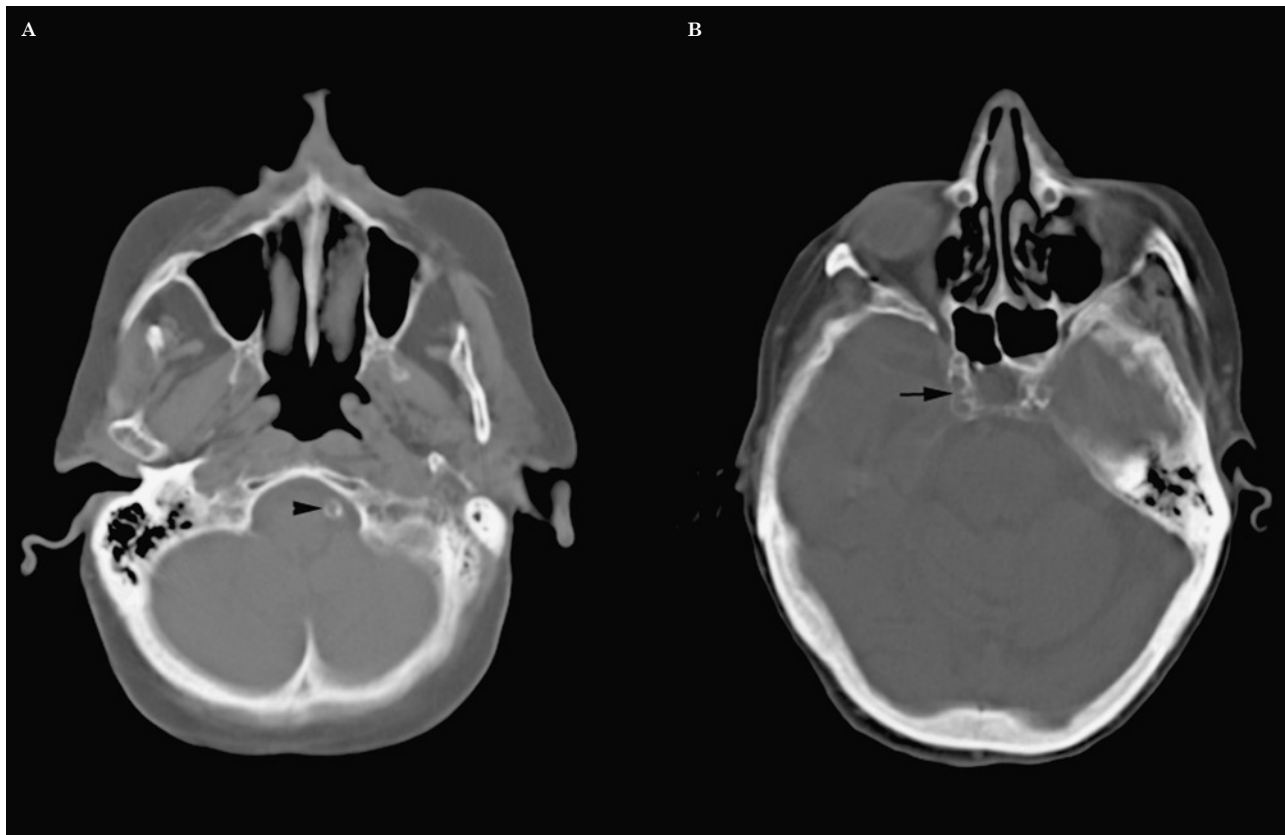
Vascular calcifications. Nonenhanced CT images showing prominent mural atherosclerotic calcifications in the left vertebral artery (arrowhead), and in both internal carotid arteries at the level of the carotid siphon (arrow).
